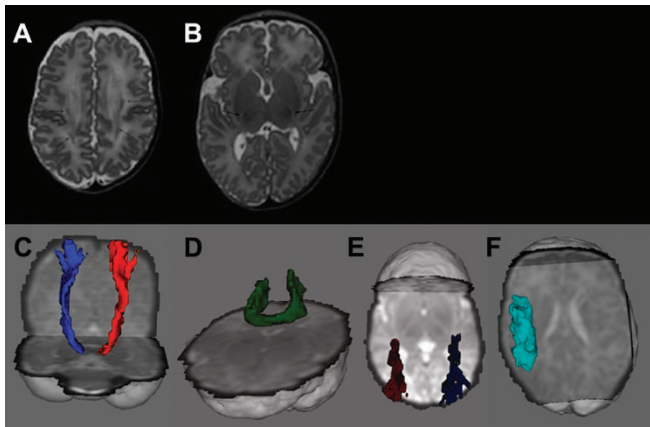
Images of the infant who had the most extensive lesions. (A) T2-weighted image at the level of the CSO. The punctate lesions are seen as low signal intensity (arrows). (B) T2-weighted imaging at the level of the basal ganglia showing abnormal high signal intensity in the PLIC (arrows). Probabilistic tractography of the (C) left (red) and right (blue) corticospinal tract, (D) forceps major, (E) optic radiations, and (F) SLF in this infant.
